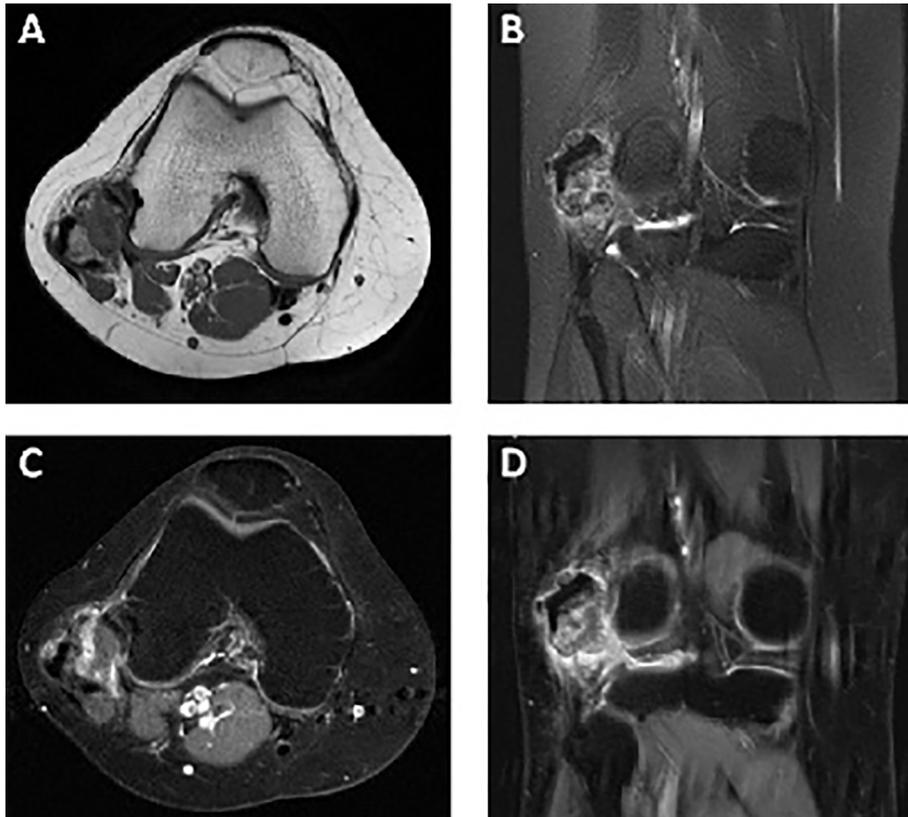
A and B Axial T1-weighted (A) and coronal T2-weighted fat suppressed (B) MR images demonstrate decreased signal intensity within the soft tissue mass corresponding to regions of mineralization on radiographs. Heterogeneous but predominantly intermediate signal is seen within the non-mineralized portion of the soft tissue mass on both T1- and T2-weighted images. C and D Axial (C) and coronal (D) T1-weighted fat suppressed post-contrast MR images demonstrate enhancement along the periphery of the soft tissue mass as well as heterogeneous enhancement within the mass. No enhancement is seen in the mineralized portion of the mass.
